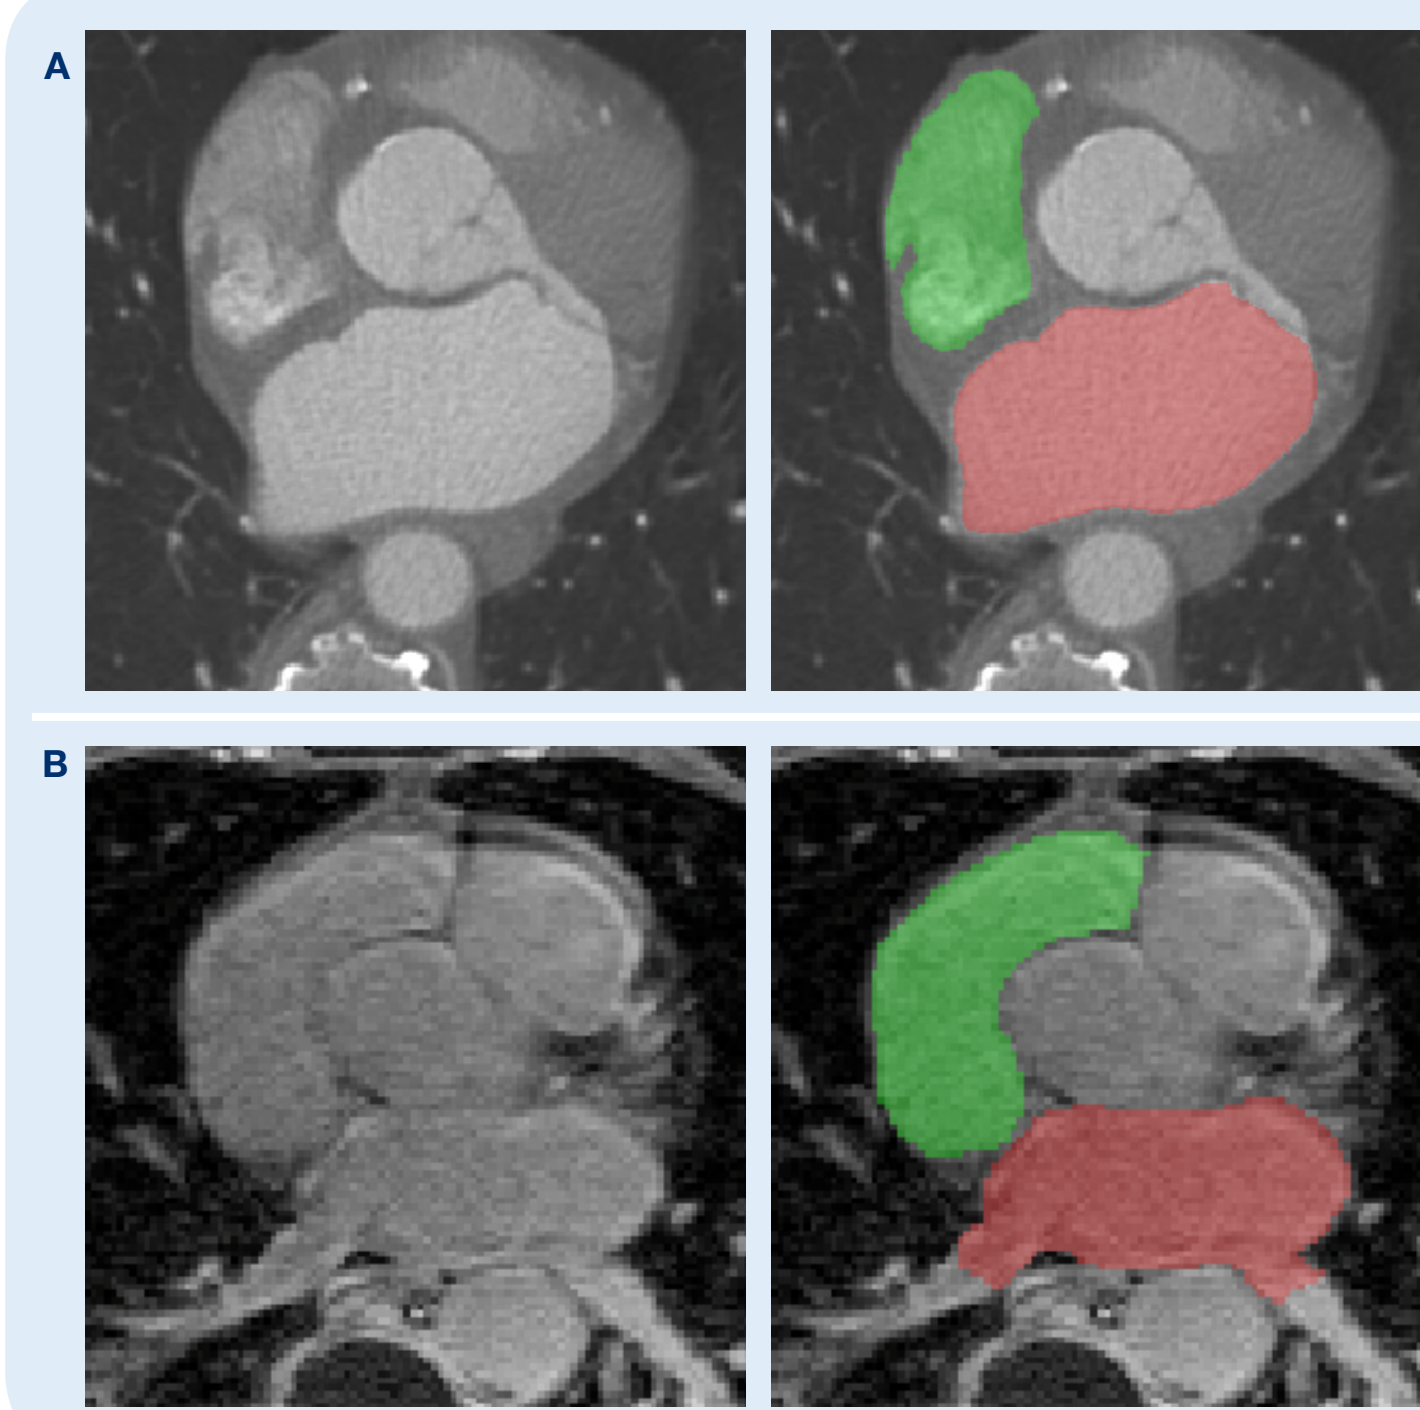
Clinical cardiac image modalities (left) that are consequently segmented (right, LA = red, RA = green) for substrate quantification. (A) computed tomography (CT) cardiac scan (B) late-gadolinium enhanced magnetic resonance imaging (LGE-MRI).
